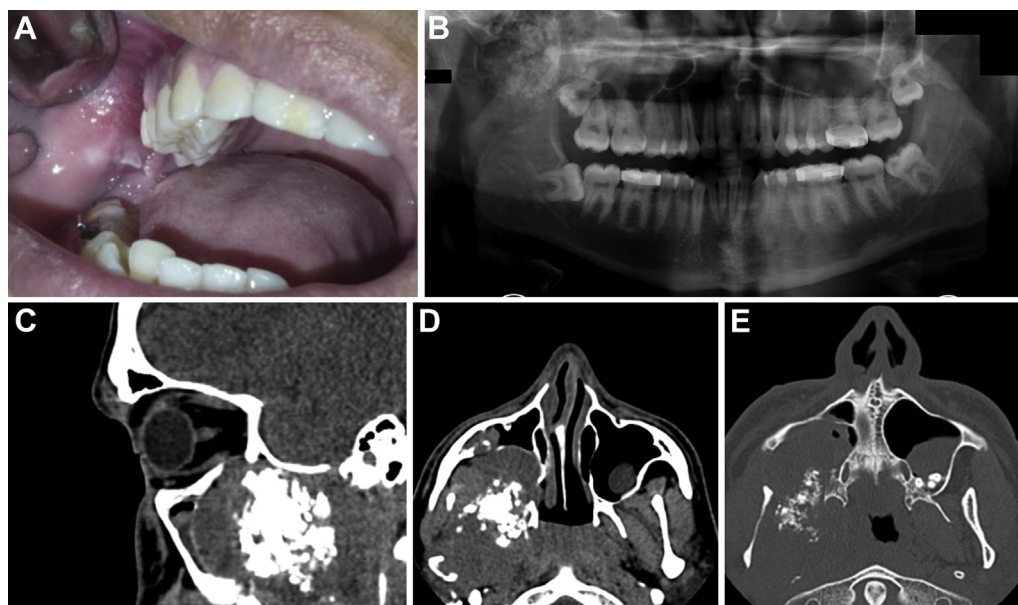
Clinical and imaging features observed in this case. A, Intraoral examination did not show any evident alteration in the maxillary mucosa of the patient. However, palpation of the affected maxillary area demonstrated a slight cortical bone expansion. B, Panoramic radiography showed an ill-defined radiolucent image, with radiopaque foci invading the maxillary sinus. C, Soft-tissue window sagittal plane of computed tomography (CT) revealed the presence of hyperdense material inside the hypodense lesion that extensively obliterated the right maxillary sinus. Soft tissue (D) and hard tissue (E) window axial plane of CT scan showing the destruction of the posterior wall of the maxillary sinus, which is almost completely involved by the tumor.
